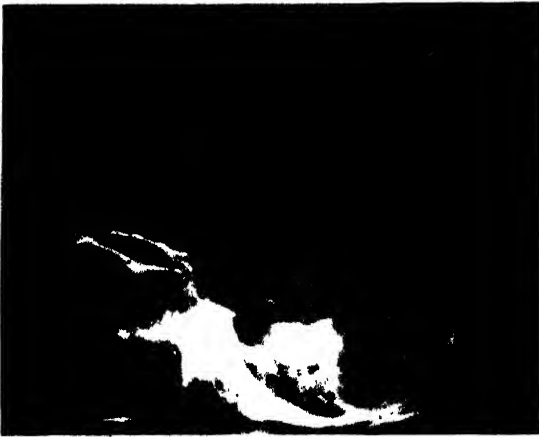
Lateral X-ray showing irregular clear area produced by a secondary deposit from carcinoma of the breast.
